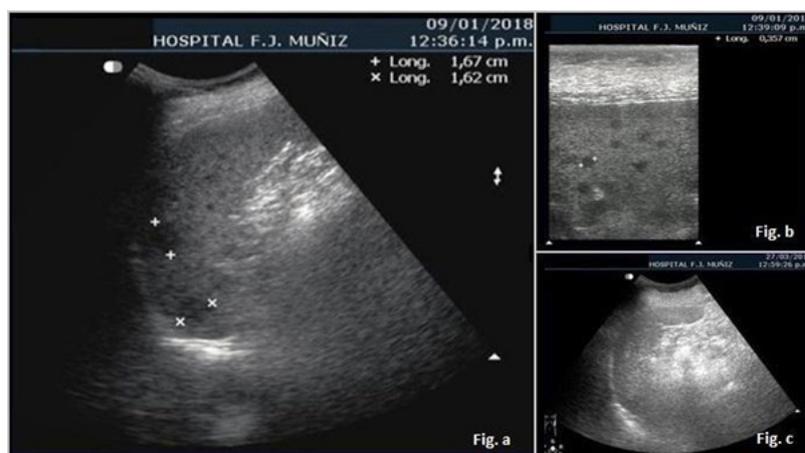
Splenic ultrasound.
